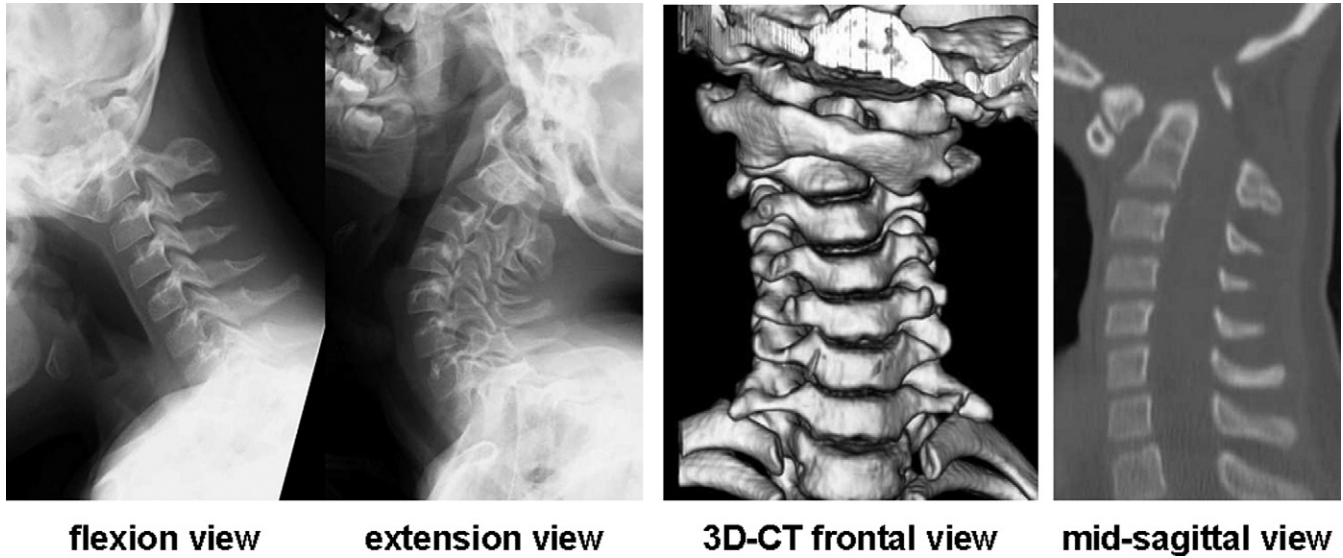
Preoperative X-ray and CT scan in case 2. On dynamic radiographs, marked instability at the atlantoaxial joint was observed. Plain CT showed atlantoaxial subluxation with os odontoideum. (3D, 3-dimensional.)
